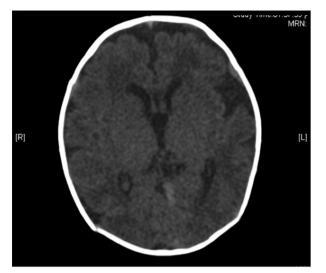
Axial section of plain brain computed tomography scan showing immature brain with no structural abnormalities.
